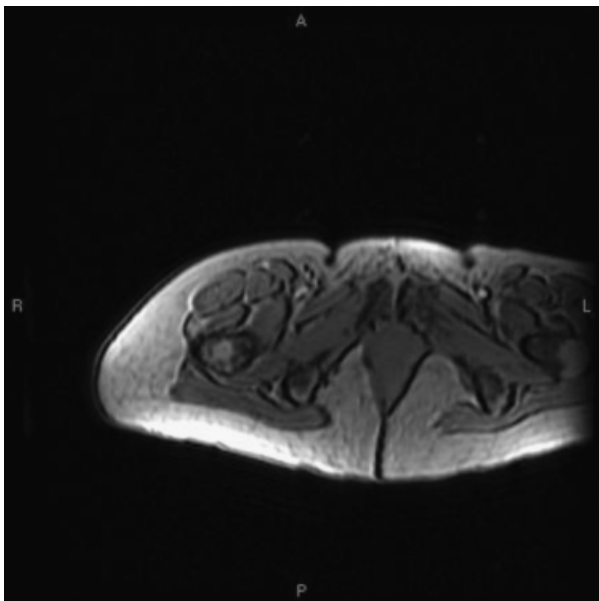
Posttreatment MRI. No changes are noted.
